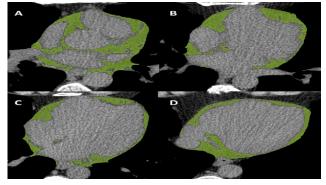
Panels (A-D) portray the process of semiautomatically identifying the epicardial adipose tissue area (depicted in green) within an unenhanced transverse CT image.
